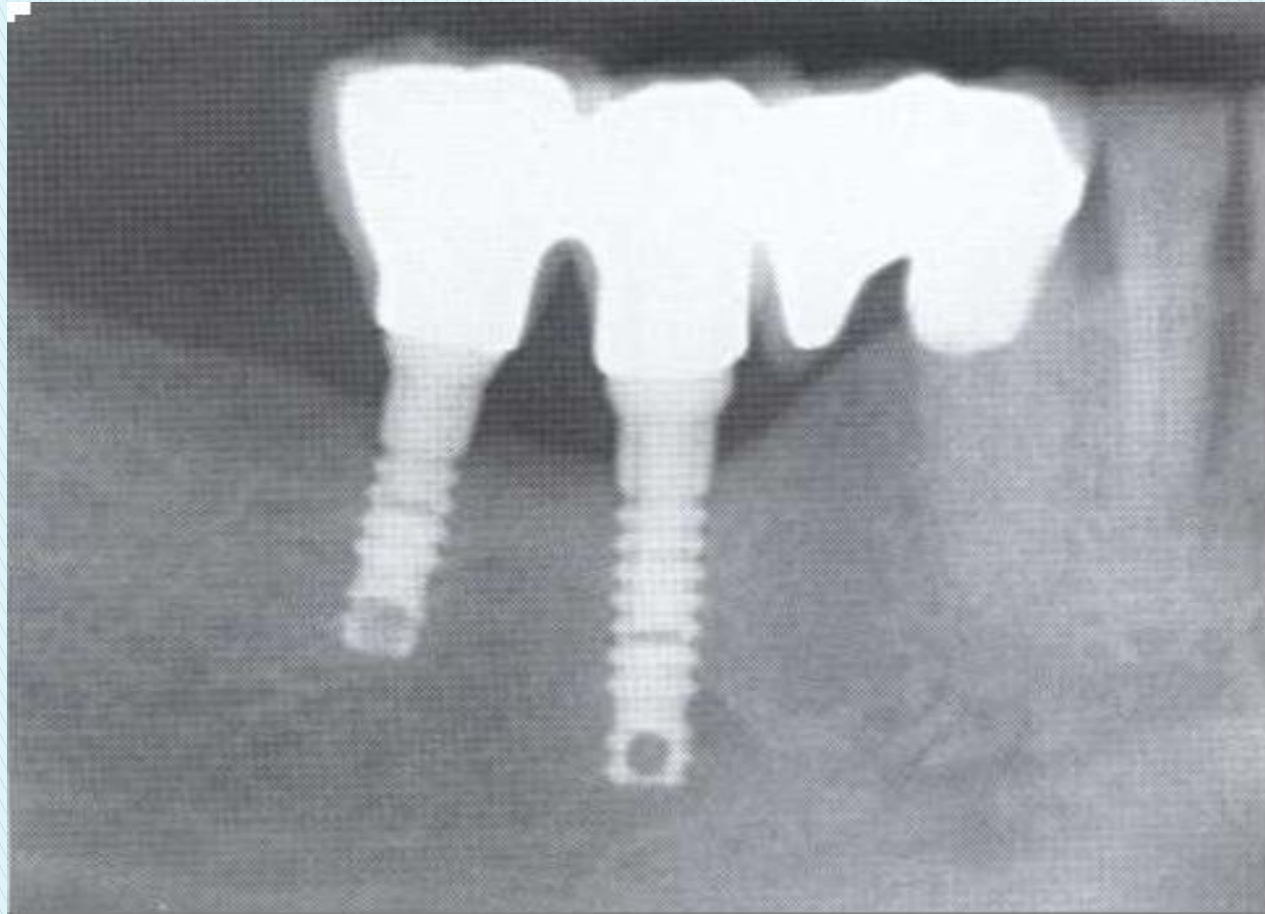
A periapical radiograph of two successful dental implants. Note the close apposition of the bone to the surface of each implant. A minor amount of saucerization is present at the alveolar crest adjacent to the distal fixture.
